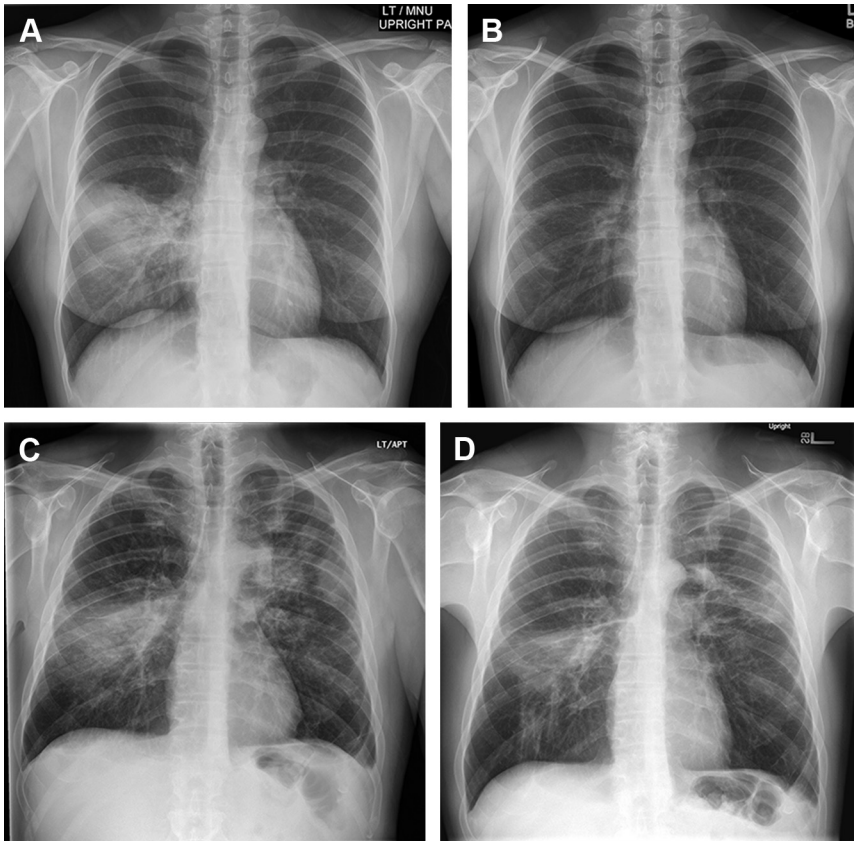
Resolution of CAP. (A, B) Two posteroanterior (PA) radiographs 2 weeks apart show nearly complete radiographic resolution of CAP in a 27-year-old woman without comorbidities. (C, D) Two PA radiographs 2 months apart show minimal improvement in legionella pneumonia. Legionella characteristically shows slow radiographic resolution, in part because of its predilection for hosts with comorbidities.
